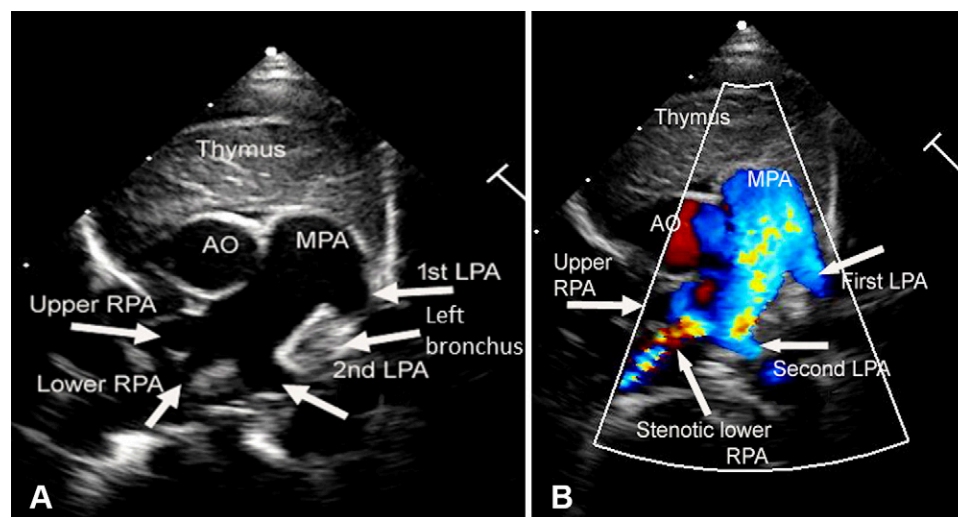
Pediatric echocardiogram of partial anomalous left pulmonary artery (PALPA) in a 4-month-old patient. (A) Grayscale and (B) color Doppler images demonstrate a second left pulmonary artery (LPA) (the PALPA) arising from the right pulmonary artery (RPA). Color aliasing is noted at the stenotic lower RPA. AO = aorta, MPA = main pulmonary artery.
